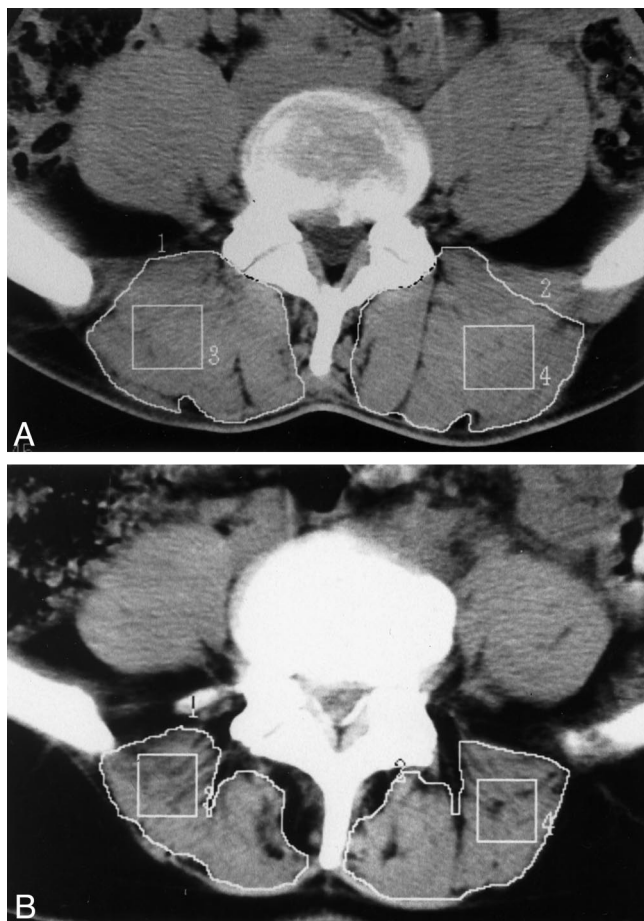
Computed tomography scans at L4–L5 of two patients with low back pain. The upper scan is from a 47-year-old man, and the lower scan is from a 48-year-old woman. The cross-sectional area was calculated within the borders of the back muscles. The muscle density was calculated both within the borders of the back muscles and within the square in a homogeneous part of the muscle.
